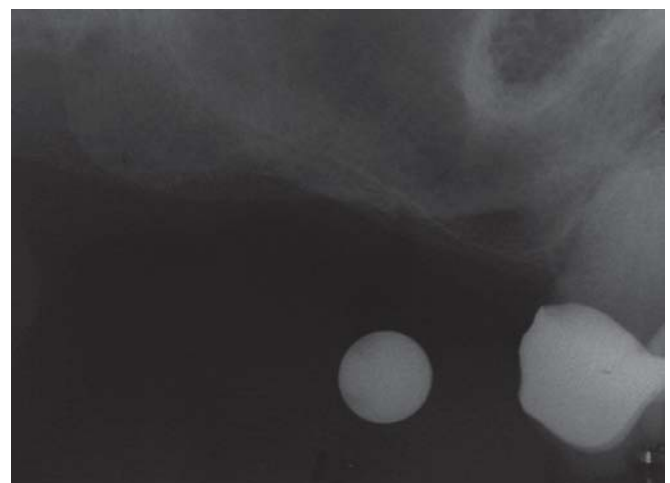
Lateral window SFE with two stages: preoperative radiograph (including a 5 mm steel ball for calibration) revealing 1 to 2 mm of subantral bone height
